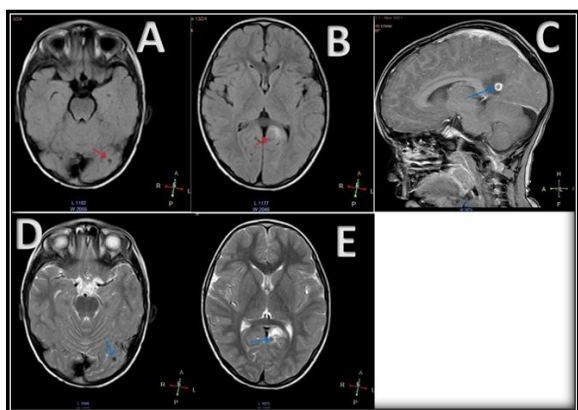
(case 3) Hypointense nodule in calcified nodular stage NCC seen in left occipital lobe on FLAIR (A) and T2 (D). Granular nodular stage NCC seen as hypointense lesion on T2(E), FLAIR(B) and CISS sequence (C) with some perilesional oedema.
